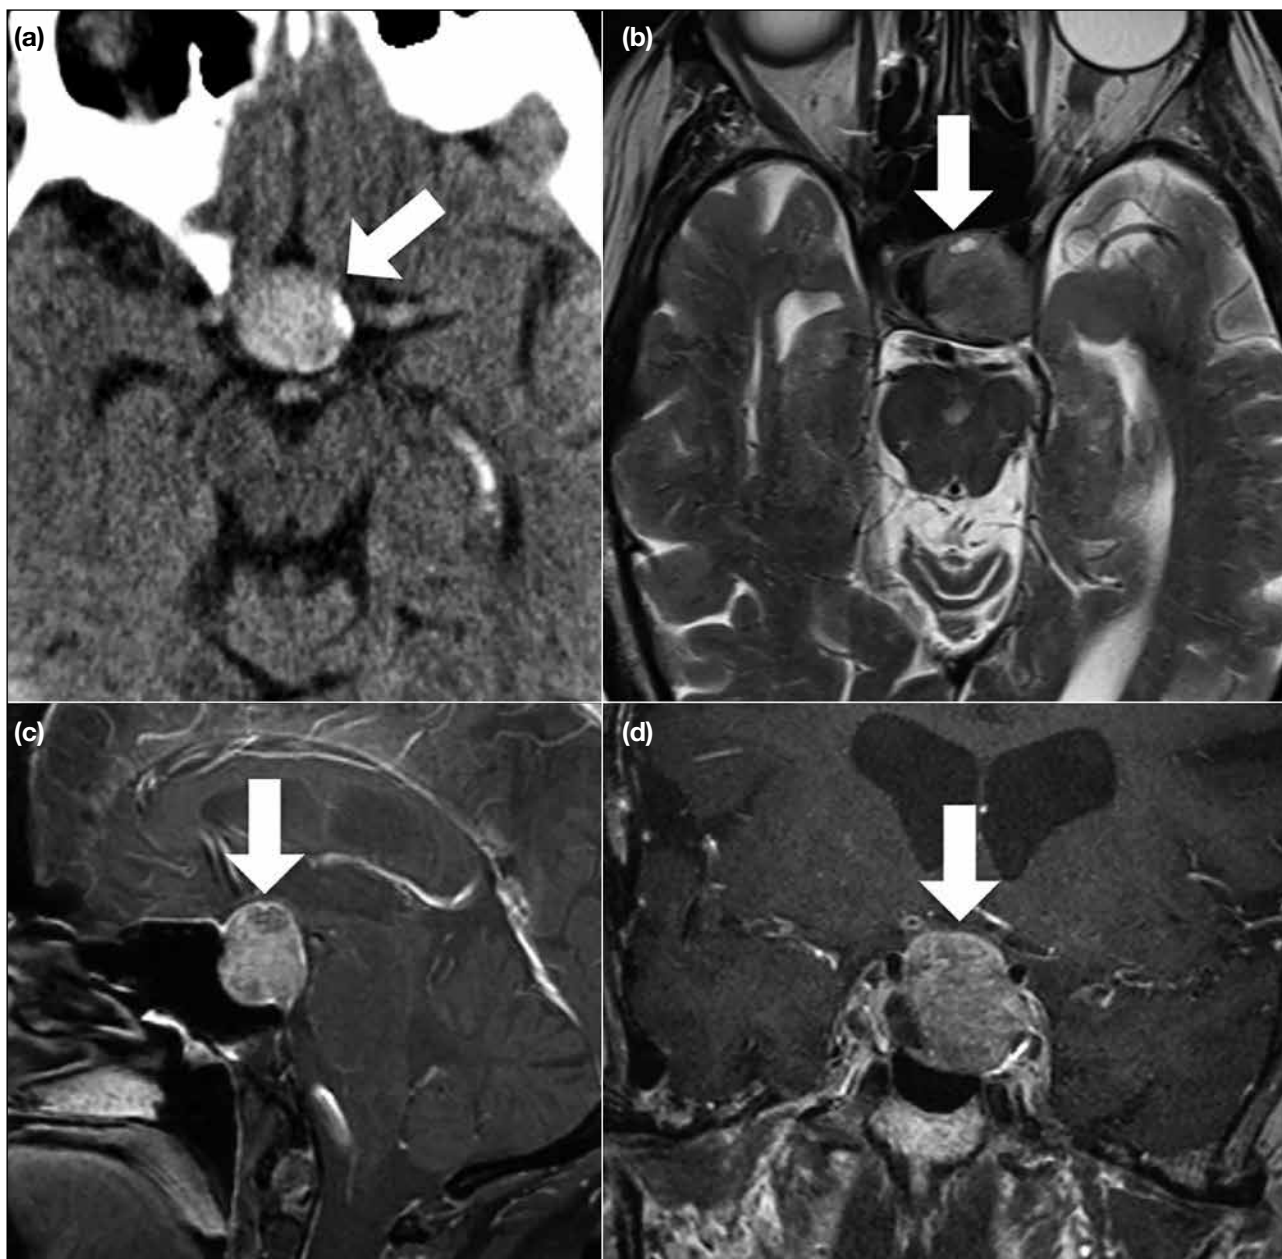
Pituitary adenoma. The tumour (arrow) involves the sellar and suprasellar regions and has marginal calcification and diffuse hyperdensity on nonenhanced axial computed tomography image (a). On axial T2-weighted image (b), the tumour (arrow) is mainly iso- to hyperintense, with focal hypointensity, possibly due to haemorrhage. The tumour (arrows) enhances heterogeneously in sagittal (c) and coronal (d) contrast-enhanced T1-weighted fat-suppressed images.
